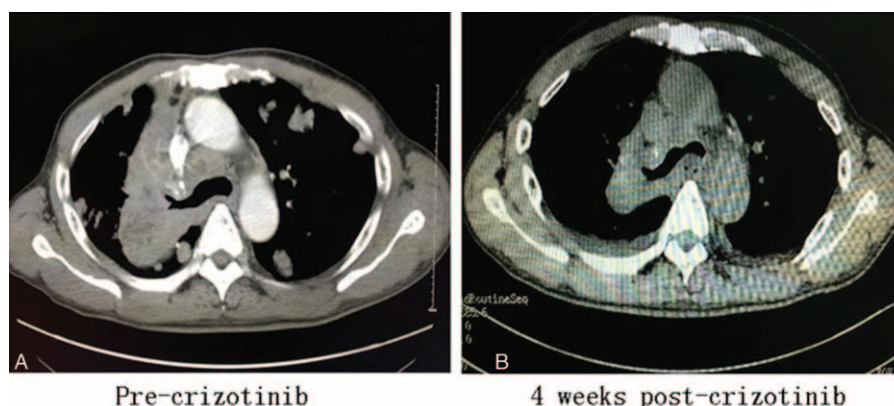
Response to crizotinib treatment. (A) Chest CT scans before crizotinib treatment showing a space-occupying mass with multiple lymph node metastases. (B) Chest CT scans after 4 weeks of crizotinib treatment showing a 42.4% reduction of the lung tumor, meeting RECIST partial response criteria.
